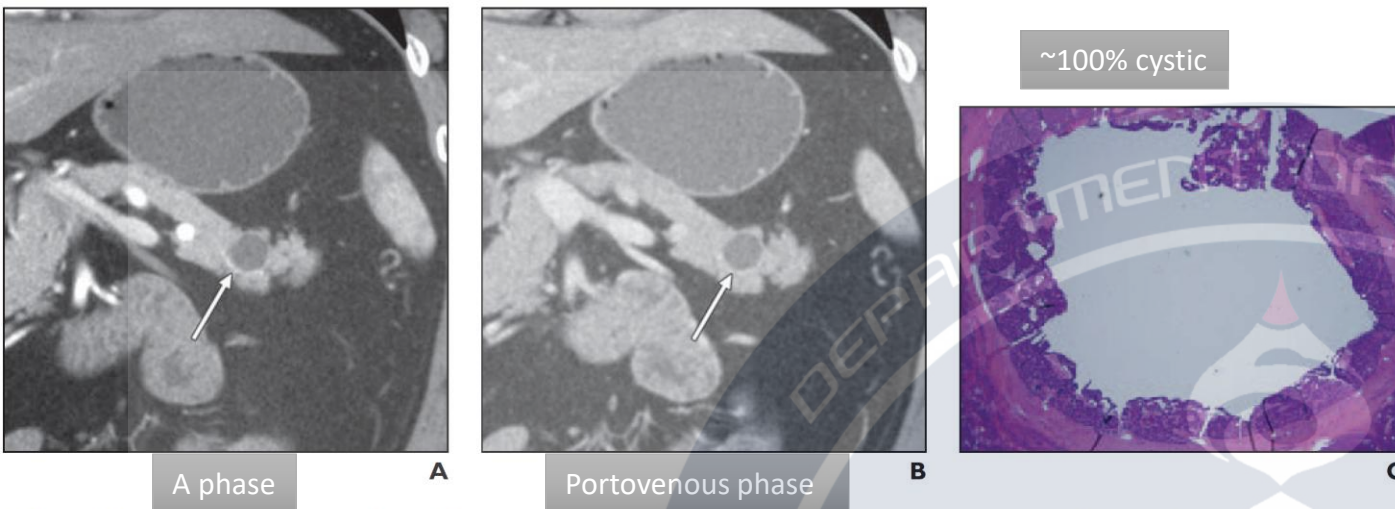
Well-differentiated neuroendocrine tumor (NET), nonfunctioning, in 56-year-old man. Cystic mass was initially found on CT performed for abdominal pain; mass had increased in size during follow-up. Fine-needle aspiration performed at another institution revealed well-differentiated NET (case 2 in Table 2).
